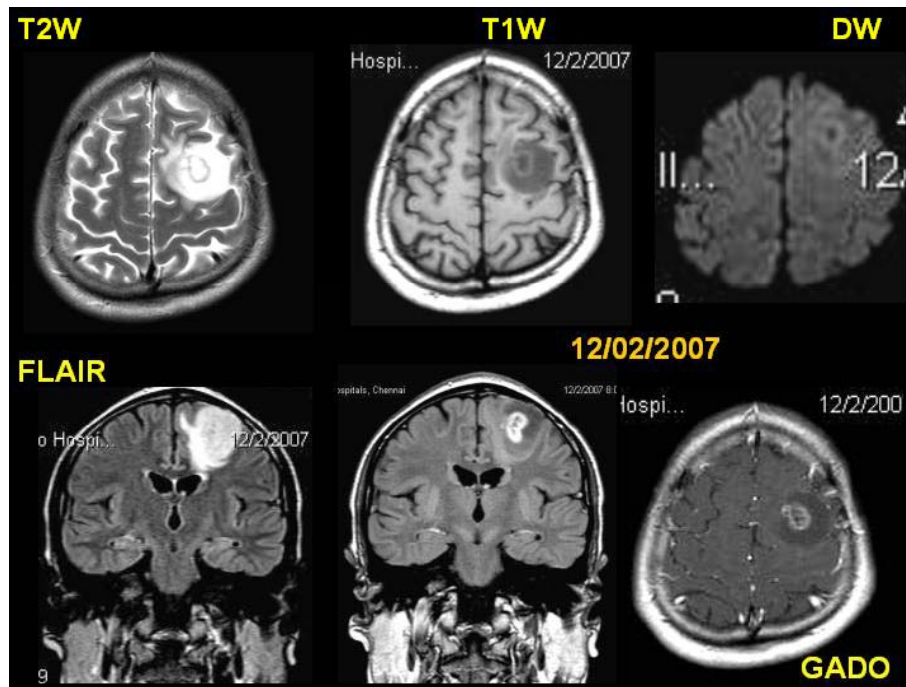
MRI shows, a small, nodular, peripheral enhancing lesion in the left frontal cortex mimicking a granuloma
